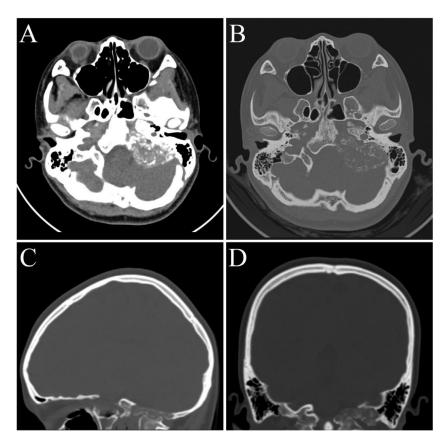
CT findings. (A-D) Three-dimensional CT images reveal multiple bone disruptions at the base of the left posterior cranial fossa, including the clivus, petrous apex, vertebrae, temporal bone, and hypoglossal canal. These areas show varying degrees of involvement, uneven density, unclear borders, and measure approximately 3.2×4.4 cm.
